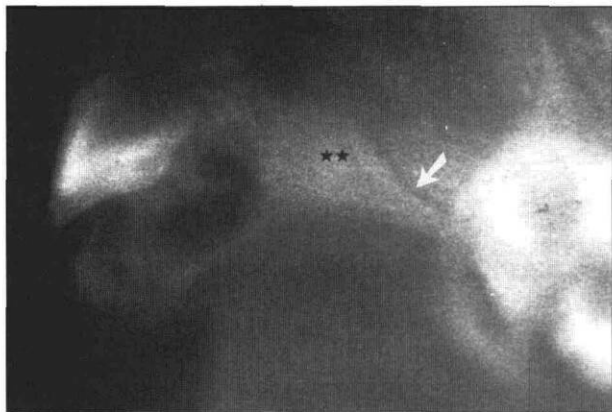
Lateral radiograph demonstrating premaxillovomer- al suture (arrow) and placement of premaxillary pin (*)
